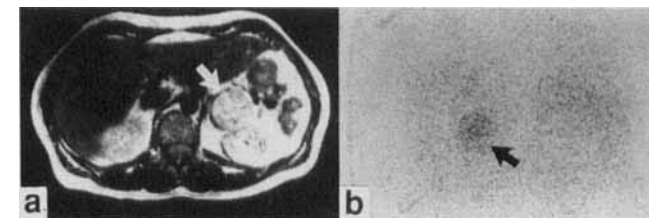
a T2 weighted abdominal magnetic resonance imaging scan of the abdomen of a 67-year-old man with episodic hypertension and elevated plasma catecholamines (E-2019 pmol/l, reference range 0–545 pmol/l, NE-6.86 nmol/l, reference range 0–4.5 nmol/l, urinary metenphrine-23.4 µmol/d, reference range <4.63 µmol/d, vanillylmandelic acid 53.9 µmol/d, reference range <35 µmol/d) and a 5 cm left adrenal pheochromocytoma (arrow). b ¹³¹I-metaiodobenzylguanidine scintiscan depicts the neoplasm as a solitary focus of ¹³¹I uptake in the left abdomen
